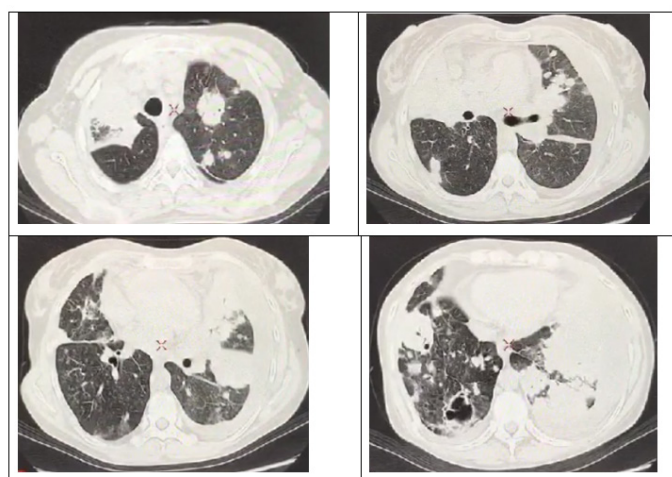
On August 31, 2024, a CT scan Showed Lung Nodules That Were Approximately 50% Larger and More Numerous Than in the Previous Study, Pleural Effusion and Bilateral Fissure, More Pronounced in the Left Lung Field, as Well as Mediastinal Adenopathy's Approximately 30% Larger than in the Previous Study and Pericardial Effusion. The Rest of the Findings Were the Same as Those Described in the Previous Study.
